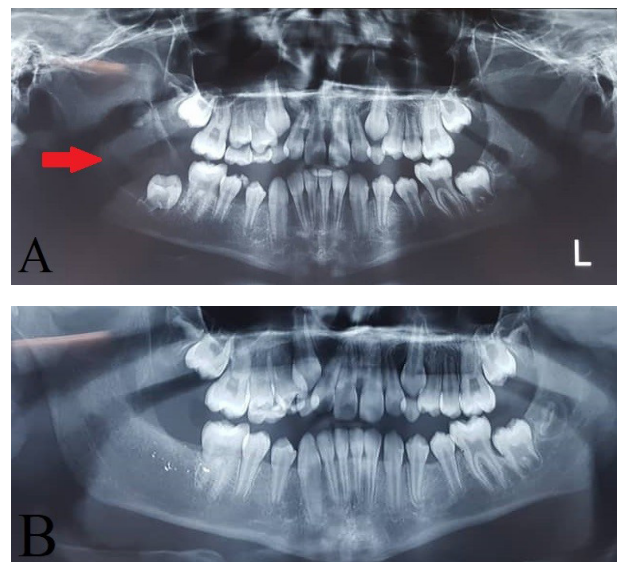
A: Reduce lesion size and repair the mandible bone after first surgery in panoramic x-ray, B: Forming visible new bone at the site of the lesion.
